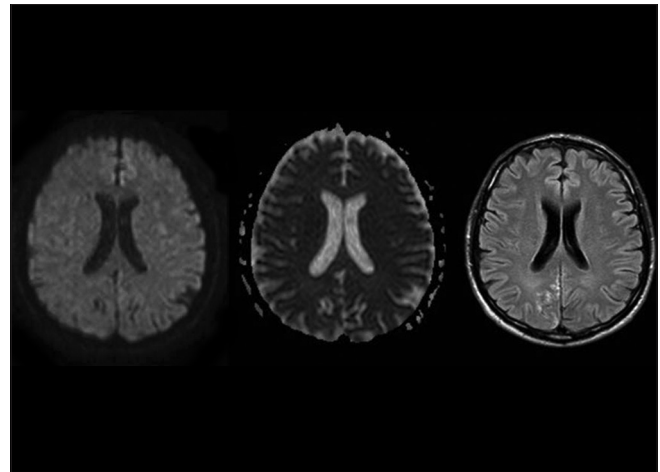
After 4 months: Diffusion-weighted imaging (on the left) and corresponding apparent diffusion coefficient map (in the middle) magnetic resonance imaging show size reduction of the hyperintensities compared to the same sequences of the affected areas. Fluid-attenuated inversion recovery (on the right) suggests both resorption of the vasogenic edema and signs of poststroke gliosis
